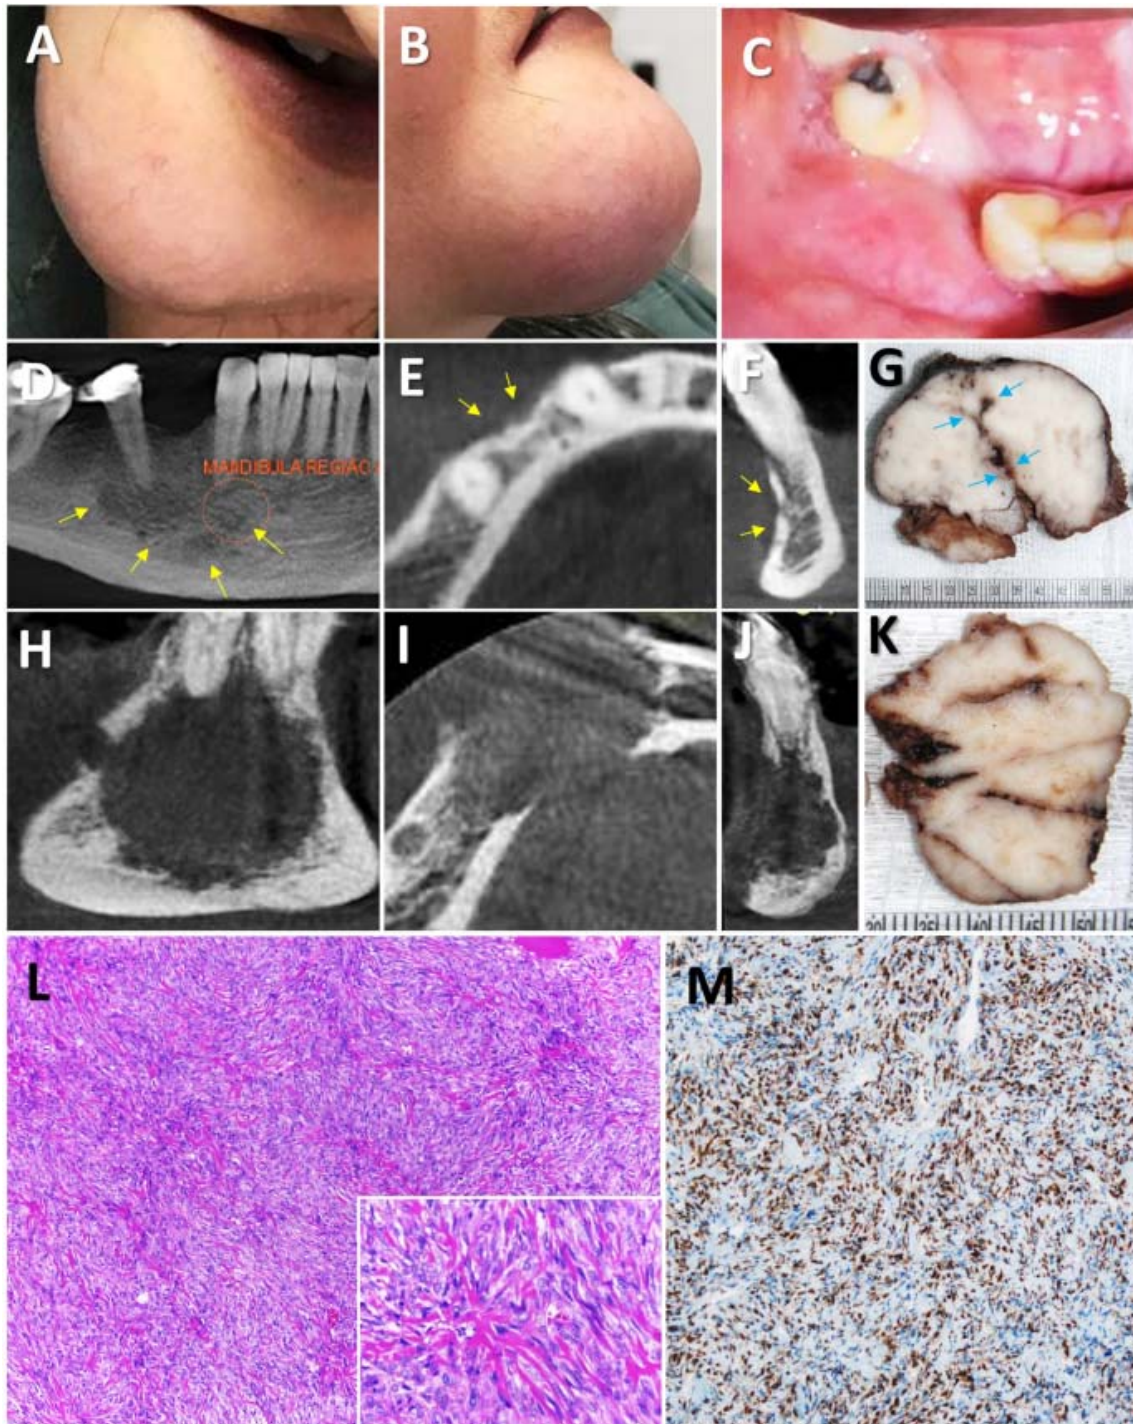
A-C: Initial clinical presentation of exuberant facial asymmetry caused by a well-circumscribed swelling of smooth surface, located in the right lower buccal vestibule. Cutaneous superficial telangiectatic blood vessels covered the lesion (A-B, extraoral examination; C, intraoral examination). D-F. The tumor exhibited an ill-defined bone rarefaction, leading to slight buccal bone cortical resorption (yellow arrows). G. Grossly, the tumor appeared as an incompletely removed soft tissue fragment of fibrous consistency and ill-defined irregular base; a central staghorn blood vessel is evident (blue arrows). (D-F, Cone-beam computerized tomography; G, macroscopic examination) H-J. Four years later, a large hypodense lesion of irregular margins was noted causing exuberant bone destruction and cortical disruption. K. the gross appearance of the persistent tumor was of an ill-defined and lobular fibrous tumor. (H-J, Cone-beam computerized tomography; K, macroscopic examination) L-M.
